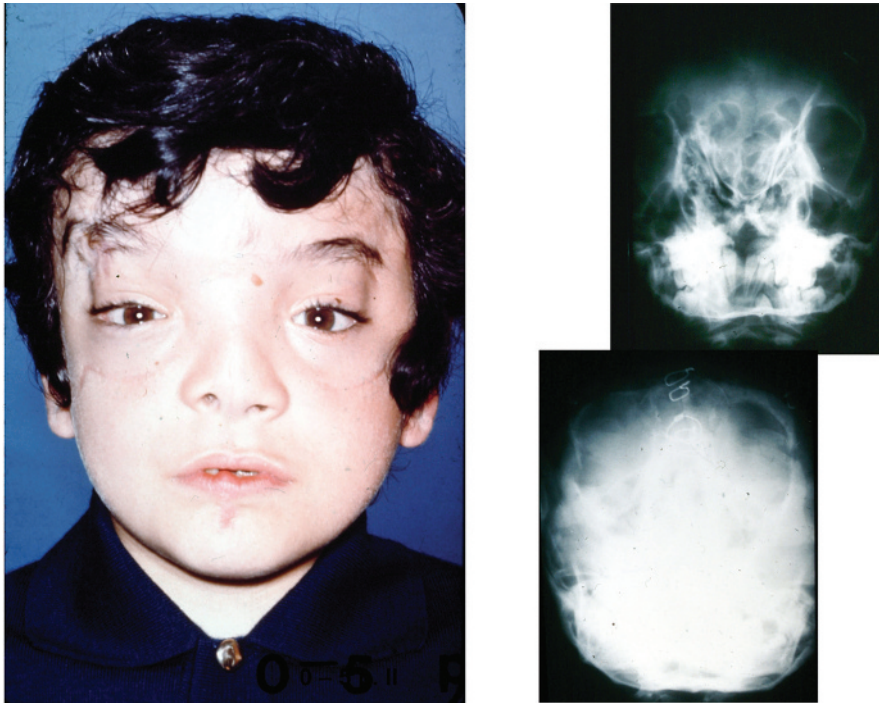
Patient after surgery plus radiograph.
